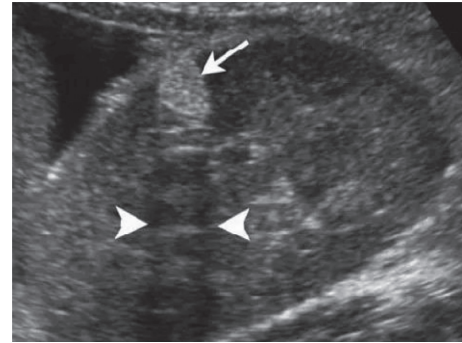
A detection image of positive tumors. Note. The black and white ultrasound image of the longitudinal section of the right kidney showed a cluster of echoes (as shown by the arrow) with a posterior sound shadow (as shown by the short arrow).
